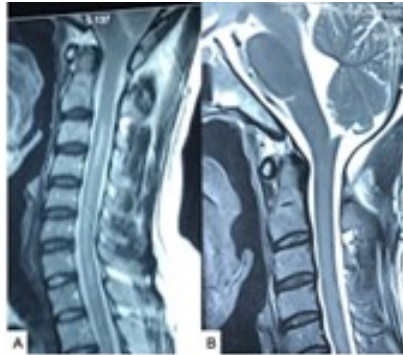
(A) preoperative MRI of cranio-vertebral junction (CVJ) and cervical spine (sagittal views) showing type 1 Chiari malformation with syringomyelia. (B) Post-operative MRI after three months of operation. Source: Figure by authors.
